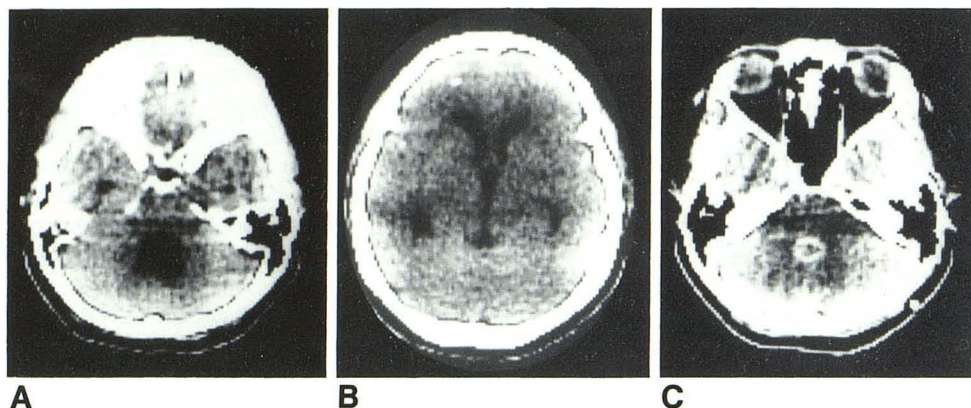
Case 3. A and B, CT scans. Dilatation of third, fourth, and lateral ventricles and intracranial calcifications. Metrizamide ventriculogram (not shown) showed cyst in fourth ventricle with outlet obstruction. C, CT scan 6 months later for increasing headache. Enhancing ring-like lesion at site of fourth ventricle, which had become totally obliterated.
